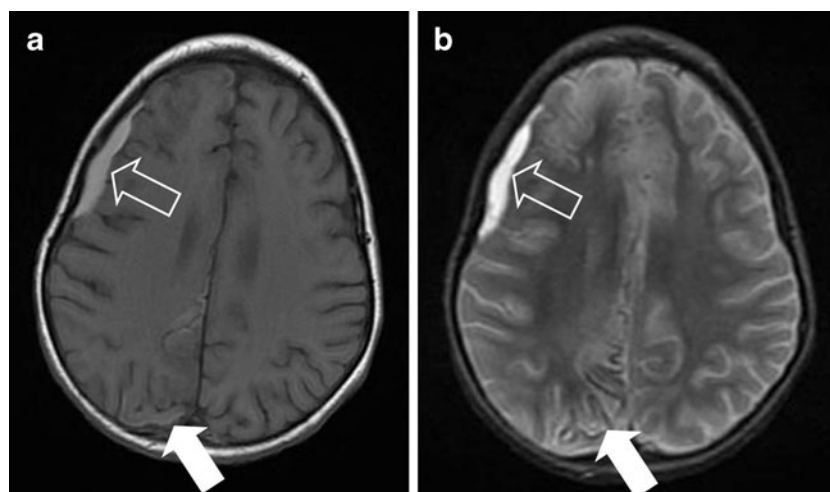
a Case 8. Axial T1-weighted MR image of a 3-year-old boy who fell from the stairs. *Information not available to the participating radiologists:* the boy was brought to the hospital comatose, according to parents he had fallen from the stairs that night. Signs of physical abuse were found all over his body. He was admitted for several weeks, this MR scan was made 2.5 weeks after the incident. Police investigations revealed that the day before admission he had been seen in good condition by
